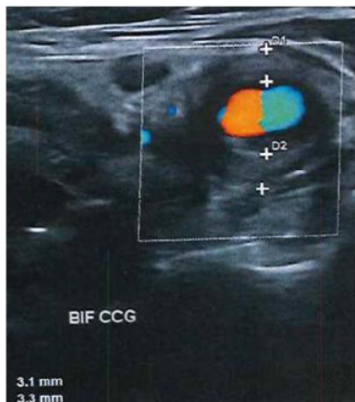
Ultrasound showing isoechoic wall thickening of the left carotid artery.
